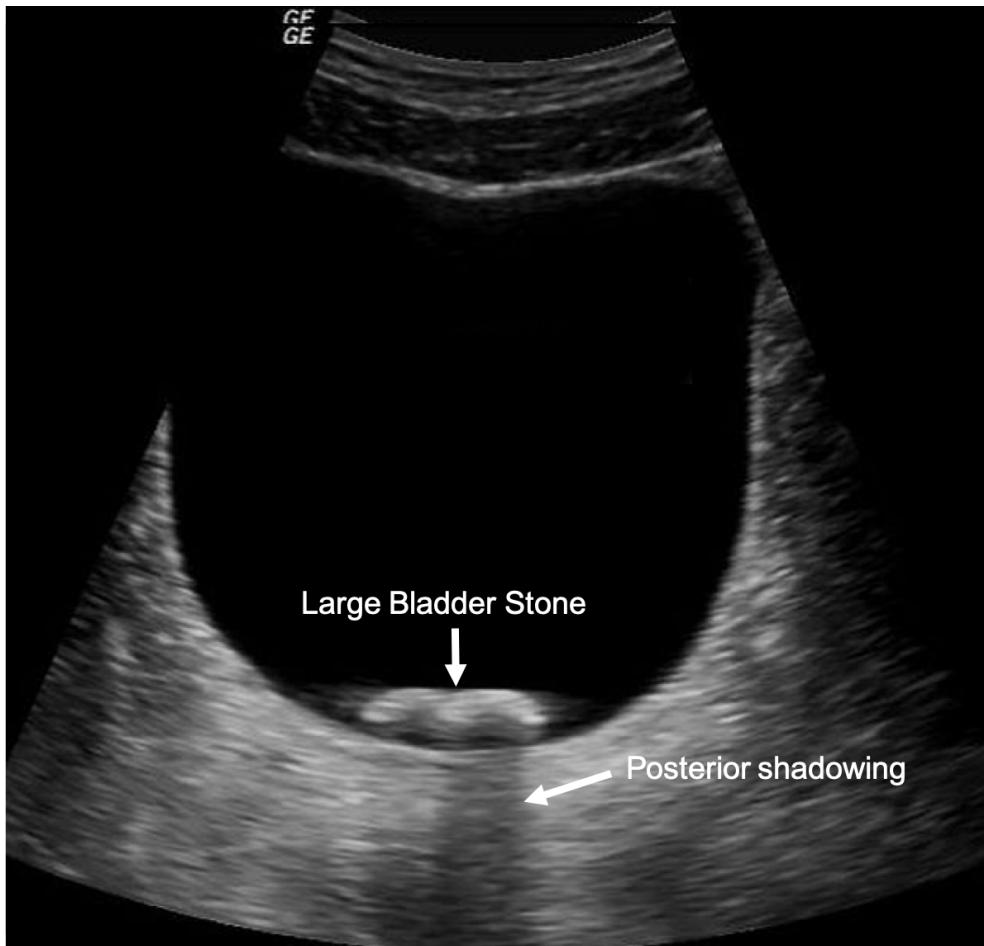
Bladder Stone. On this bladder ultrasound, a large bladder stone is visualized along with a posterior shadowing artifact.
